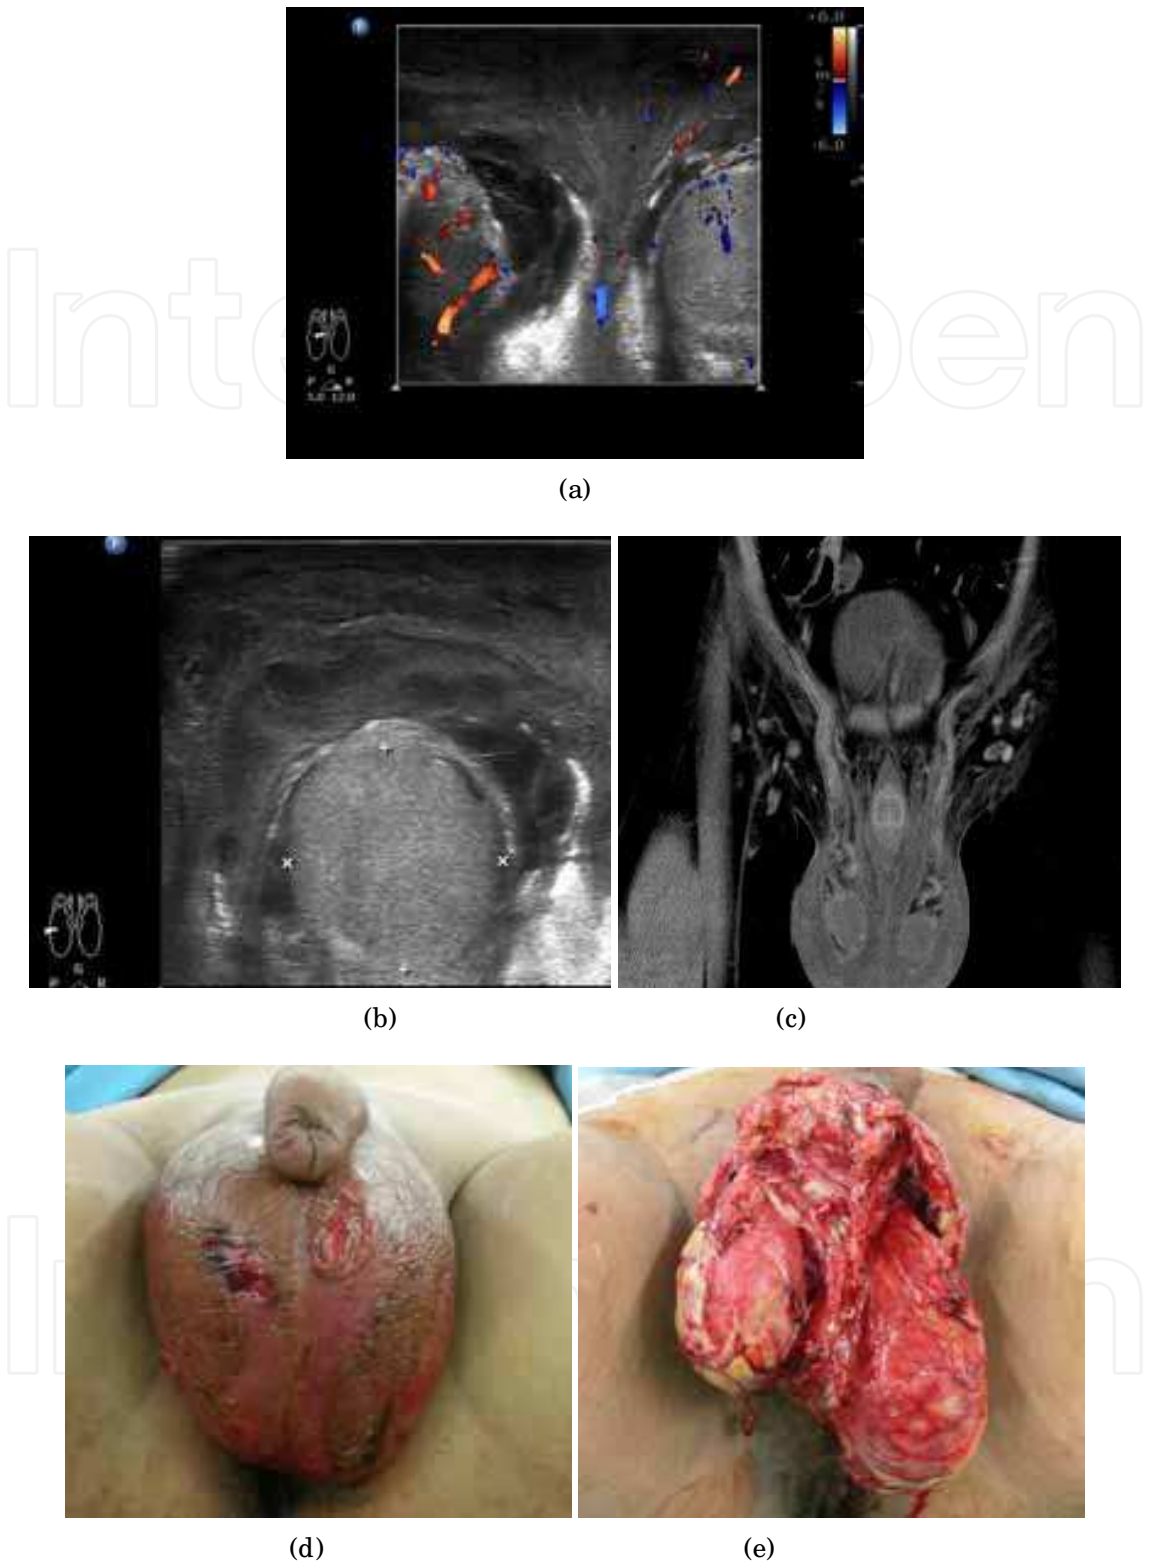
A 27-year-old male presented with scrotal pain. (a,b) Enlargement, heterogeneous echogenicity, and increased vascularity of the bilateral epididymis with bilateral scrotal wall thickening on sonography. (c) Edematous scrotal wall on CT scanning. (d) Gross appearance of the scrotum. (e) Intraoperative view, showing that large amount of necrotic tissue should be removed
